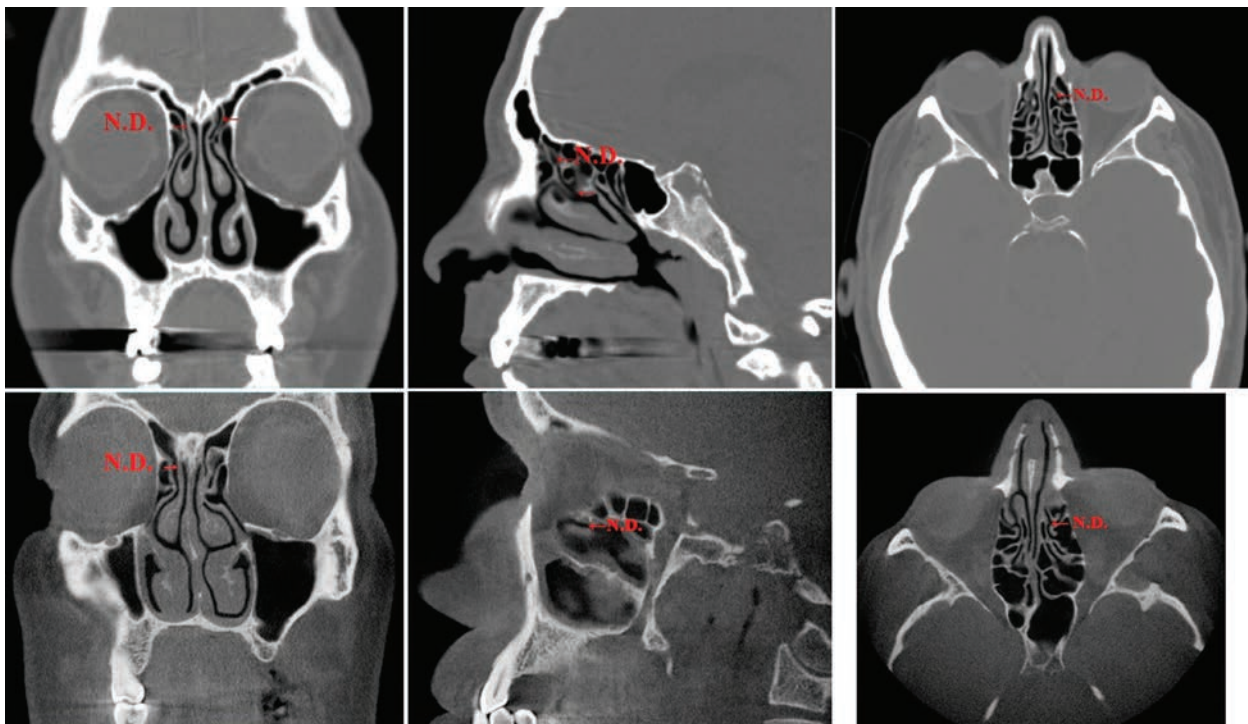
Coronal, sagittal and axial sections of standart-CT (up) and CBCT views of Nasofrontal duct/frontal recess including frontal sinus
